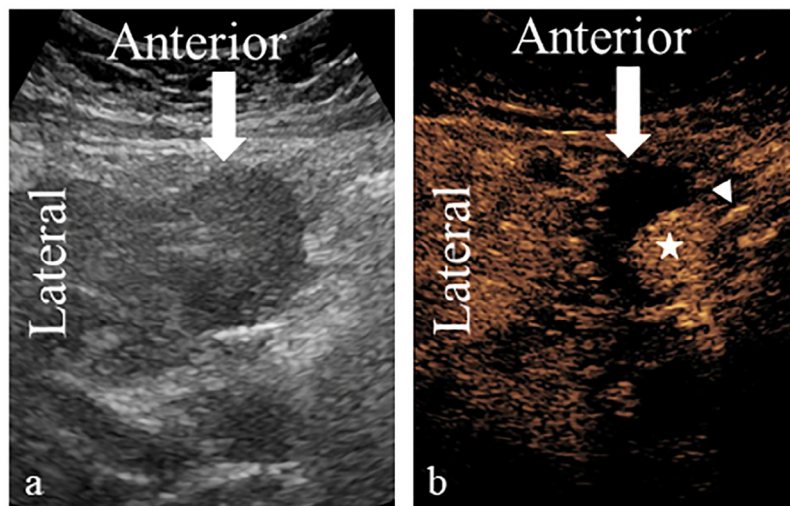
Two weeks after transarterial chemoembolization treatment #2, contrast-enhanced ultrasound was performed to monitor for residual tumor viability as part of an experimental protocol. (a) Grayscale hepatic ultrasound demonstrates a heterogeneous hypoechoic tumor (arrow). (b) Contrast-enhanced hepatic ultrasound demonstrates post-treatment cavity (arrow) and presence of vascular residual tumor (star). Traceable extrahepatic collateral is identified (arrowhead). This was traced back to the gastroduodenal artery.
